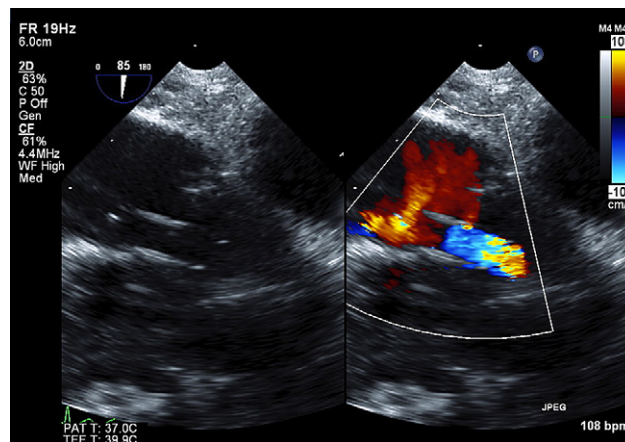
Two-dimensional transesophageal echocardiographic image of a VV ECMO return cannula in the right atrium. Note the additional flow out the cannula side holes.
